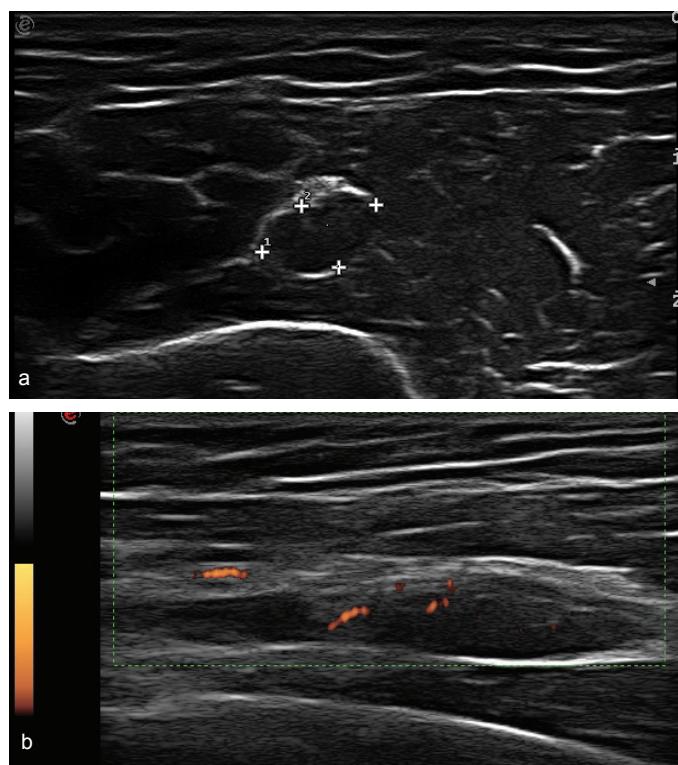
a) Short-axis view of the enlarged radial nerve before its entrance into the supinator muscle, b) Long-axis view of the enlarged radial nerve with vascularity on power Doppler.
